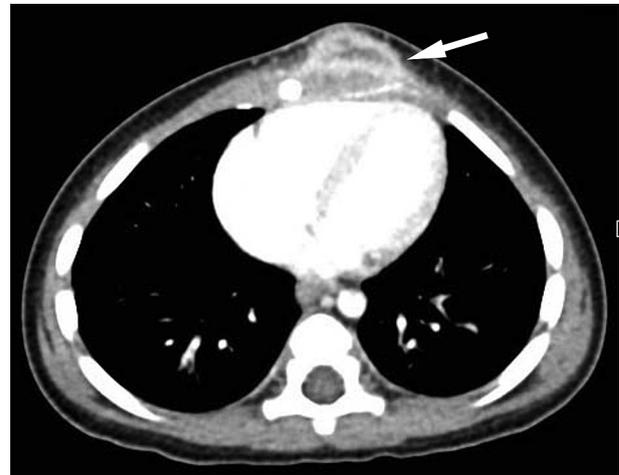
Chest computed tomography scan at low lung field reveals fusiform abscess at sternum with central necrosis (arrow).
